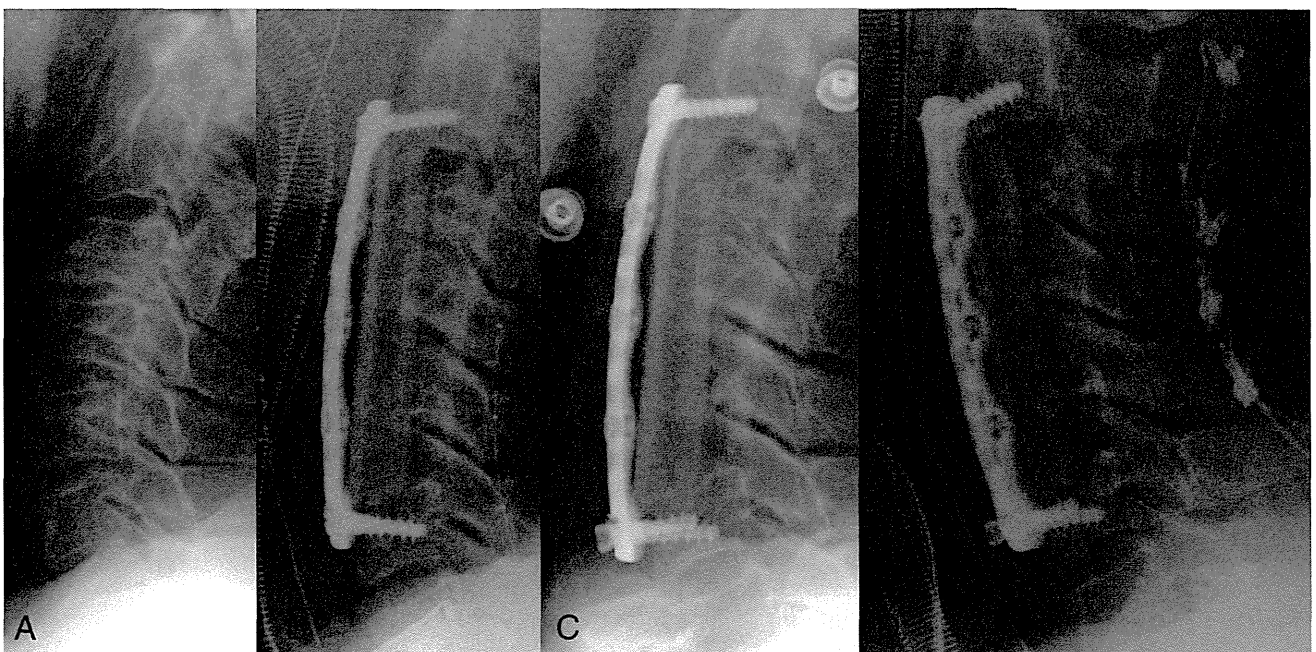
Preoperative radiograph of a 61-year-old man shows mixed-type OPLL with a fusion area lordotic angle of 25.8° (A). C2–C6 fusion was performed using an autologous fibular graft and a rotationally dynamic plate. Note the retention of the C6 endplate just after the operation (B). Graft subsidence and migration with screw pullout occurred 3 weeks after surgery (C). After in situ spinous process wiring, the degree of the patient’s cervical lordosis decreased. However, solid fusion was observed (D).
